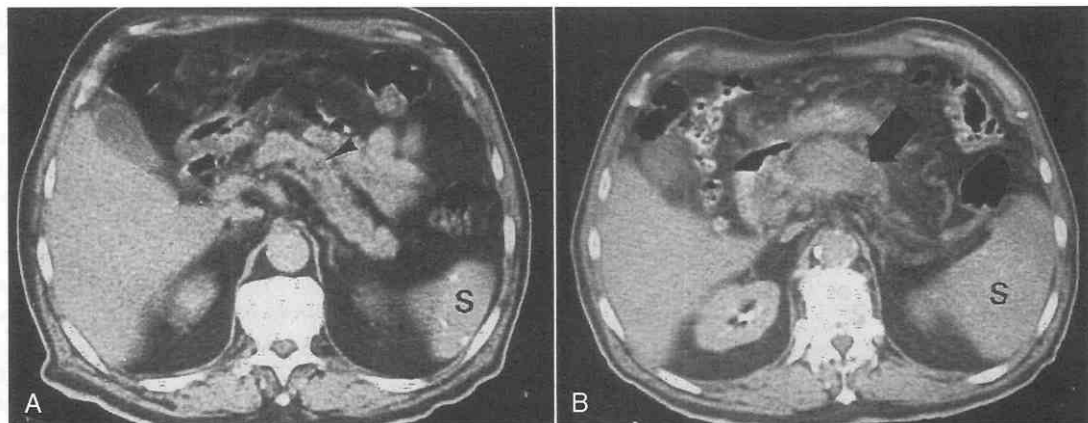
Small intraglandular tumor. *A*, CT scan performed early in the clinical course shows a subtle enlargement of the pancreatic duct and a tiny low-density area in the body (*arrowhead*). Note the normal-sized spleen (*S*). This study was not read as abnormal. *B*, Repeat CT scan months later shows a large mass in the body of the gland (*arrow*). There are numerous collateral vessels in the mesentery and enlargement of the spleen (*S*), indicating definite occlusion of the splenic vein.
